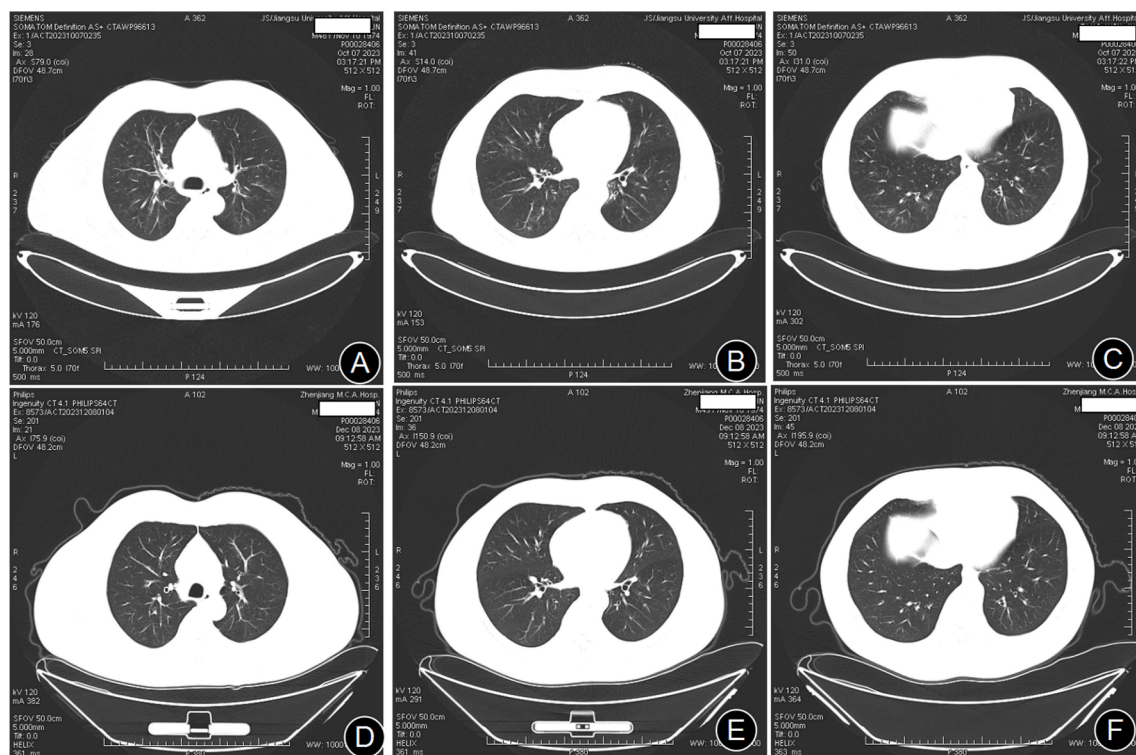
The computed tomography of case two pre-treated (A–C) and pro-treated (D–F) with Voriconazole at different levels. After one-month treatment, the lesions were absorbed obviously.
